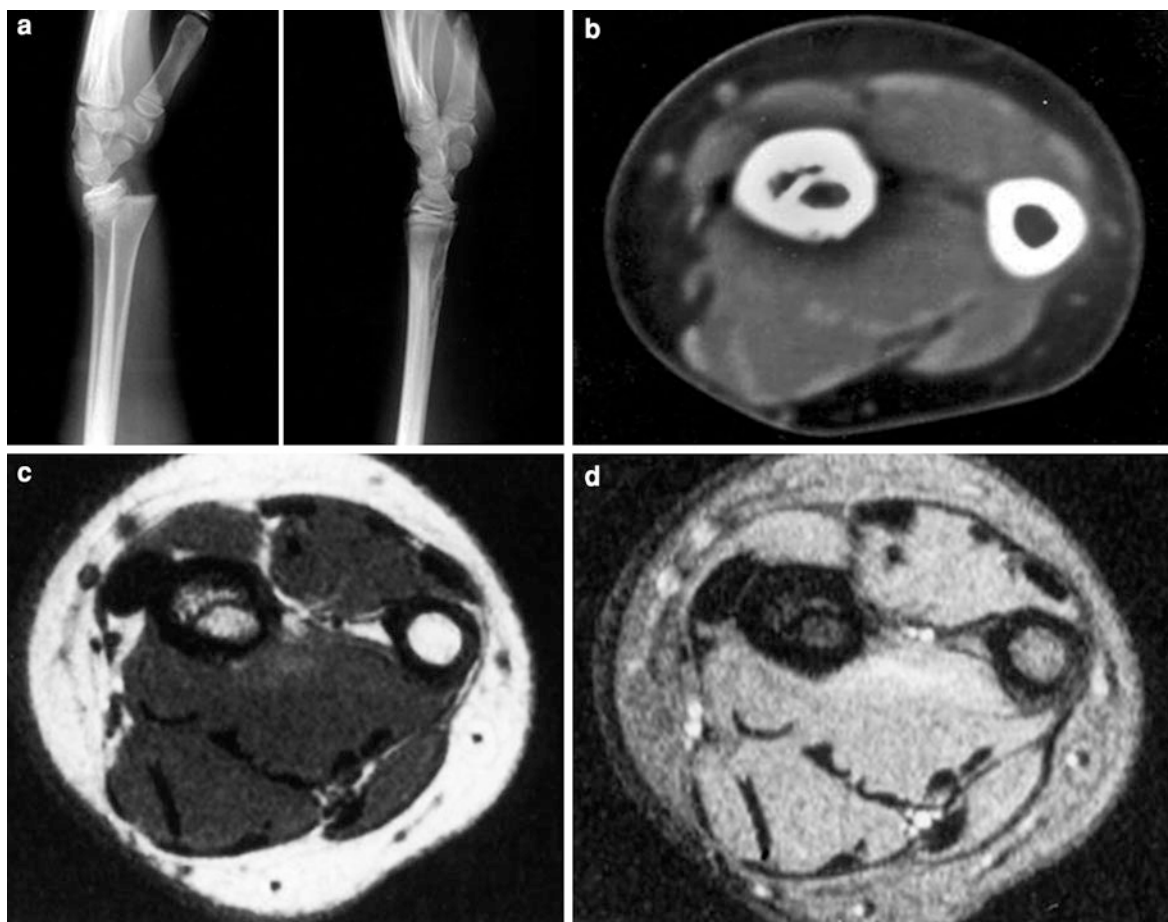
a Lateral radiograph at time of injury demonstrating a Salter-Harris type 2 injury (left image) Later radiograph with fracture healed but cystic change evident on volar cortex (right image). b CT of lesion shows cystic area lies within cortex.
